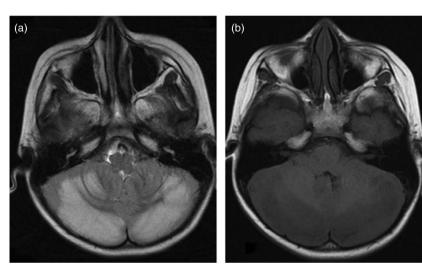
Axial T2-weighted image (A) showing hyperintense and T1WI (B) showing hypointense lesions in grey matter of the both cerebellar hemispheres.
